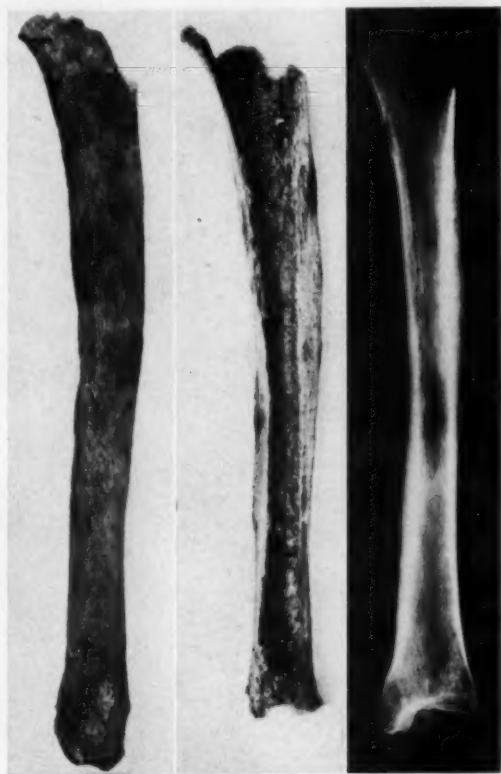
The left tibia of the same Mound Builder as was the right tibia shown in figure 39 (case 2 from Ohio, this article). The roentgenograms of both tibias were made by Dr. E. C. König, Buffalo General Hospital. (Original photographs.)
